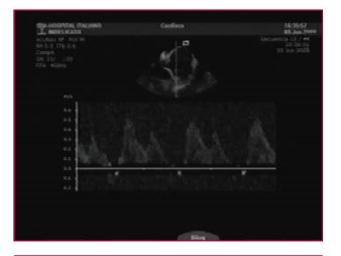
Image obtained with intracardiac echocardiogram in which is visualized the left inferior pulmonary vein.
